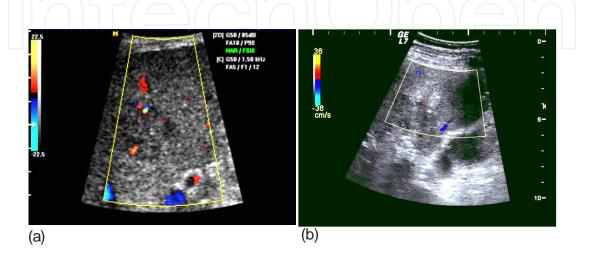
a. HCC before therapy. 2D ultrasound and color Doppler examination. b. Same case, standard ultrasound and color Doppler examination after RFA. We remark that the dimensions of the post-RFA lesion are larger than the dimensions of the initial tumor.
